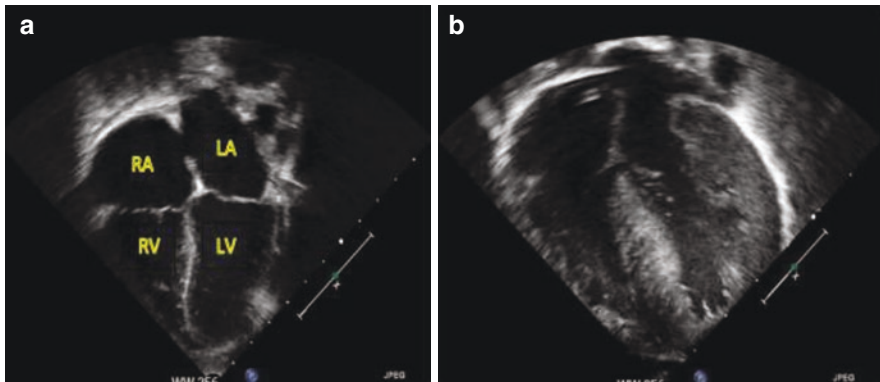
Echocardiogram of a patient with normal heart (a) and a patient with hypertrophic cardiomyopathy (b). RA right atrium, RV right ventricle, LA left Atrium, LV left ventricle
